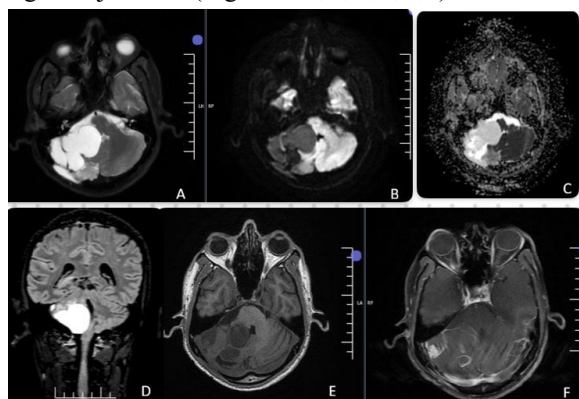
MRI brain(plain with contrast)- 2025 showing enhancing nodule in CPA angle.
